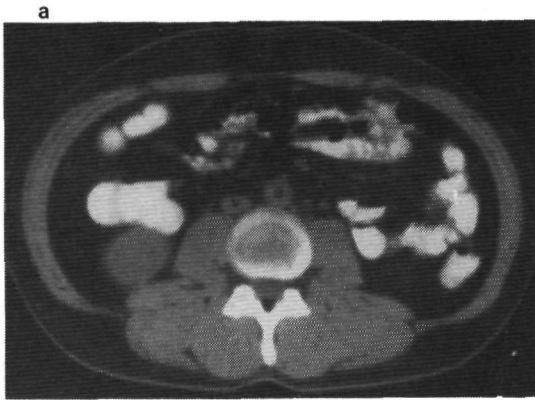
Male patient of 32 years with HD, nodular sclerosing type. Normal-sized nodes on CT (1a). Lymphography reveals minimally enlarged nodes with diffuse, foamy appearance, suggestive of HD (1b).
